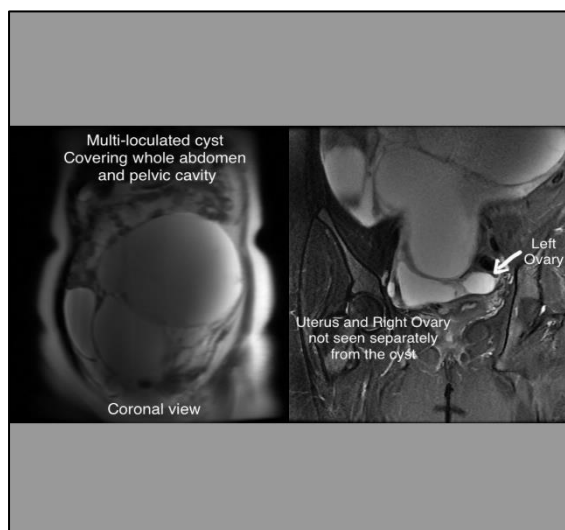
MRI plates showing extent of cyst.
